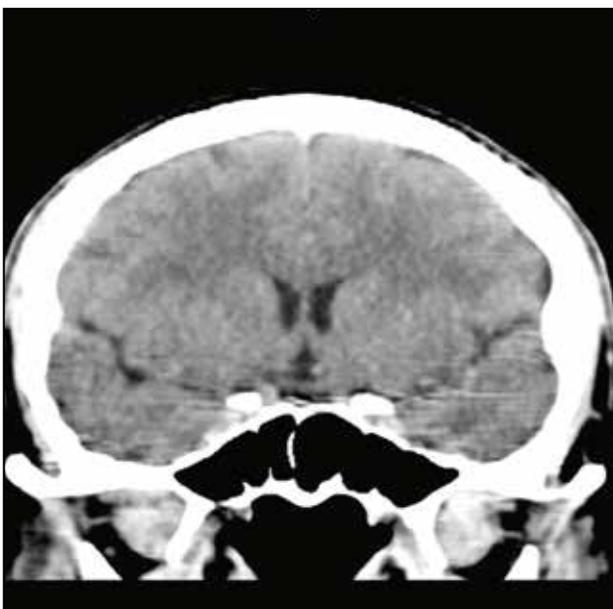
Crano-facial CT performed on day 30 postoperatively (coronal and axial section) – normal appearance of the paranasal sinuses.
